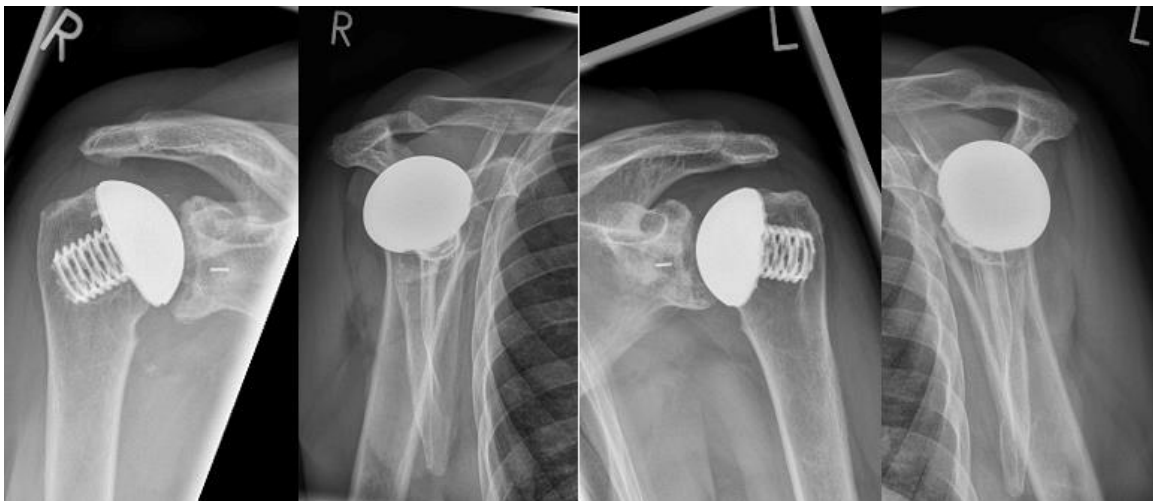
Postoperative x-rays showing bilateral total shoulder replacement.
